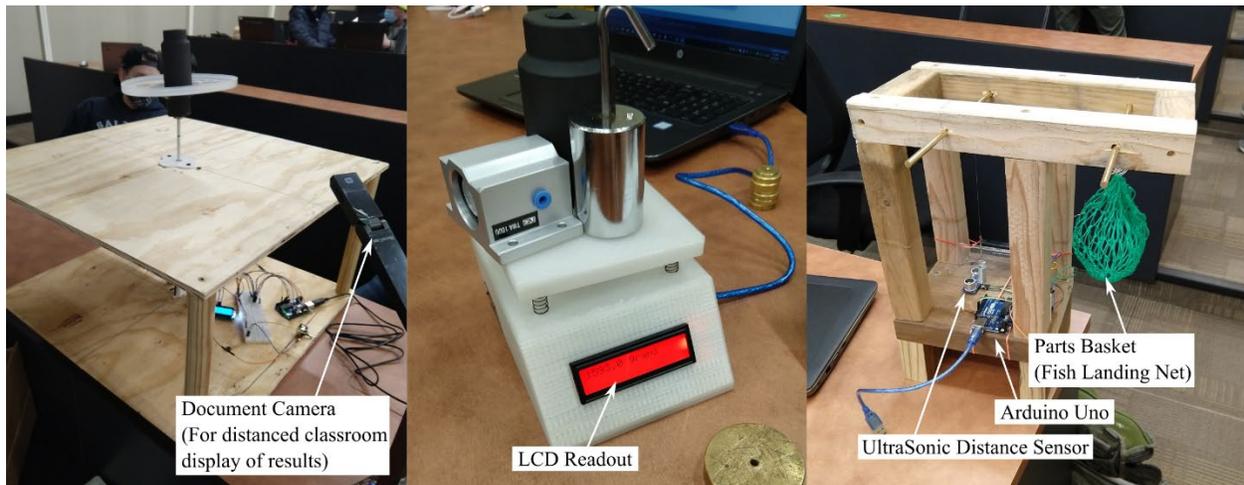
Example student balances. The left balance utilized a rack and pinion connected to a rotary potentiometer to convert the linear motion of the plunger to a mass value. Due to Covid-19 distancing requirements, a document camera that projected the testing for all students to see in real-time was used. The team that made the middle balance leveraged 3D printing to package all of the electronic components. Lastly, the rightmost design measured the deflection of their spring with an ultrasonic distance sensor.
